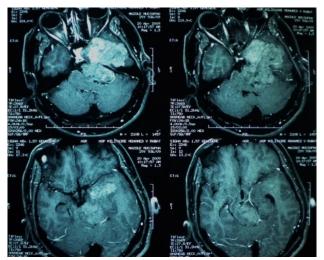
Brain MRI showing the location and extent of the tumor
